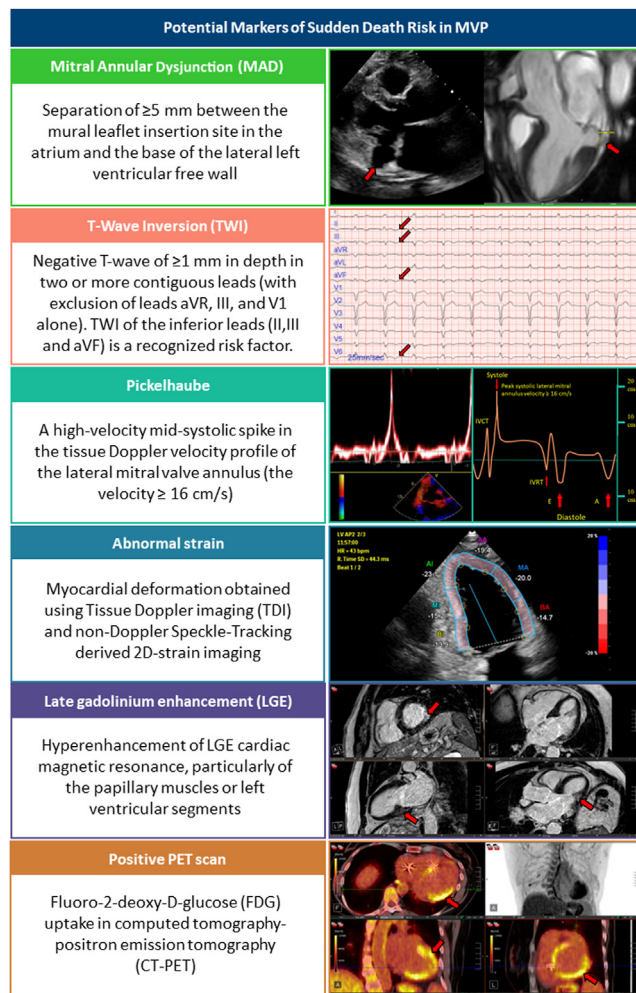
Possible phenotype presentations of mitral valve prolapse (MVP). There are multiple phenotypic potential presentations of mitral valve prolapse, including Pickelhaube sign, late gadolinium enhancement (LGE) on cardiac magnetic resonance (CMR), inflammation on computed tomography–positron emission tomography (CT-PET), and mitral annular dysjunction (MAD) on transthoracic echocardiography and CMR. FDG = fluoro-2-deoxy-D-glucose; TDI = tissue Doppler imaging; TWI = T-wave inversion.
